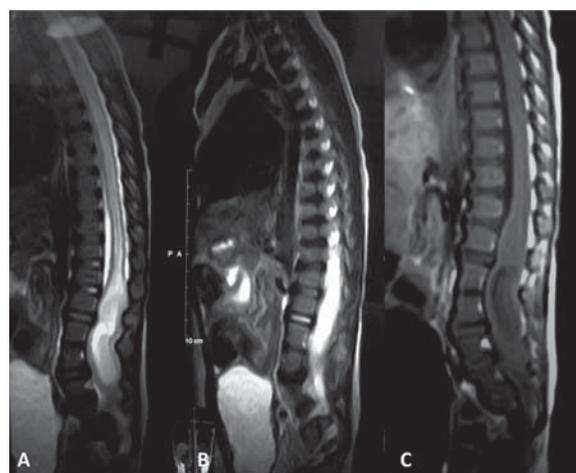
MRI dorsolumbosacral spine, A, B) T2W images C) T1W image showing intramedullary spinal abscess
